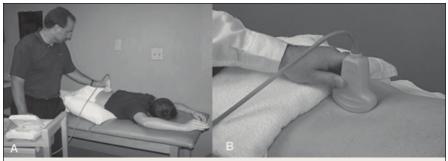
Measuring muscle thickness change of the lumbar multifidus with ultrasound imaging during a prone upper extremity lifting task (A), and the transducer orientation (B) used to generate the parasagittal view.
